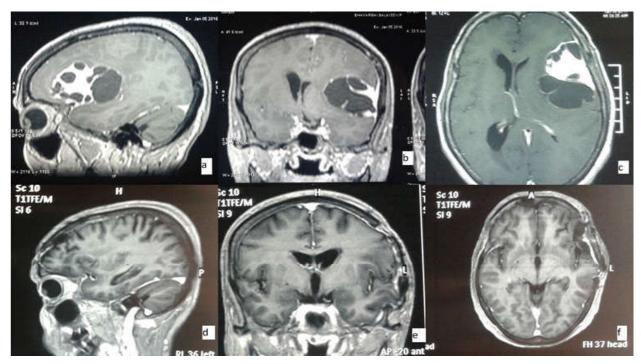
Pre and Post Operative MRI images in a case of Lateral Sphenoid wing Meningioma in a 55 year old male showing complete resection (a-c: Pre-operative, d-f:post-operative images)
